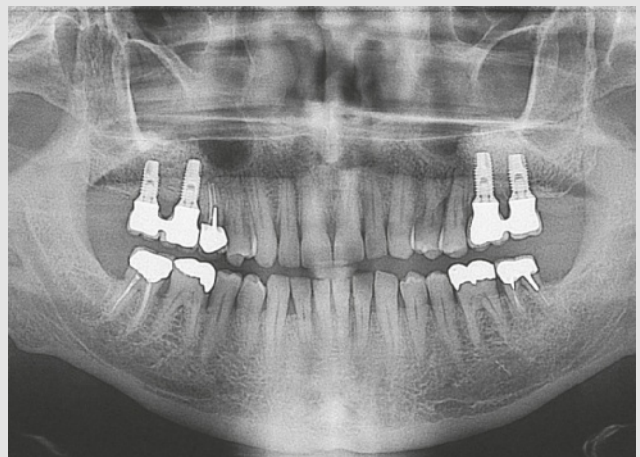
Panoramic radiographic control 1 year after completion of the treatment.
